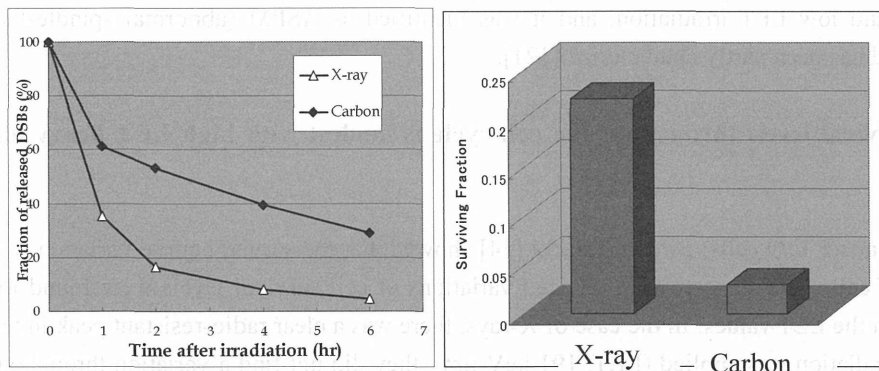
(Left) Comparison of DNA DSB repair kinetics in DU-145 tumor cells irradiated with X-rays and 70 KeV/ $\mu\text{m}$  carbon ions. (Right) Cell survival levels (4 Gy) with corresponding irradiation sources are also provided.
